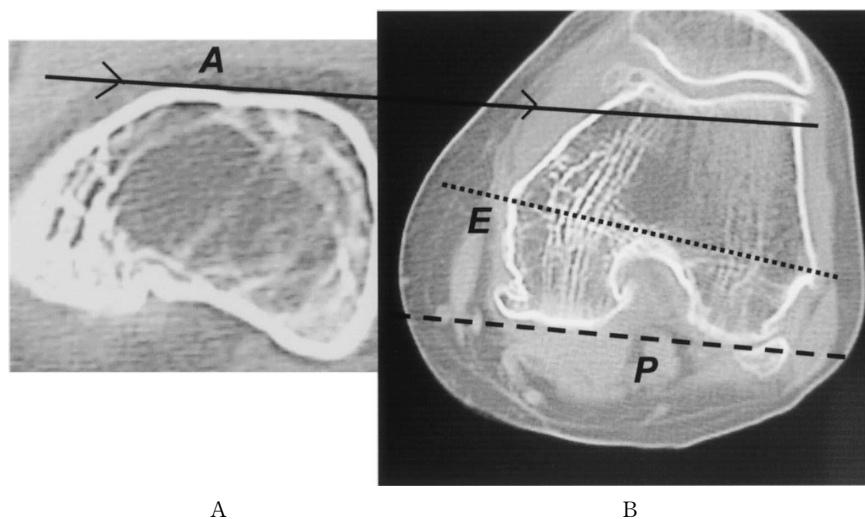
Sequential CT in a patient with medial compartmental knee OA (left knee). Three anatomical axes are drawn in Figures 1A and 1B. The angle between the posterior condylar axis (P) and the supracondylar anterior surface of the distal femur (A) is approximately 3 degrees. Therefore, line A is 3 degrees internally rotated relative to the posterior condylar axis. Line A shows the extension of the anterior surface of the supracondylar distal femur. E indicates the transepicondylar axis.
